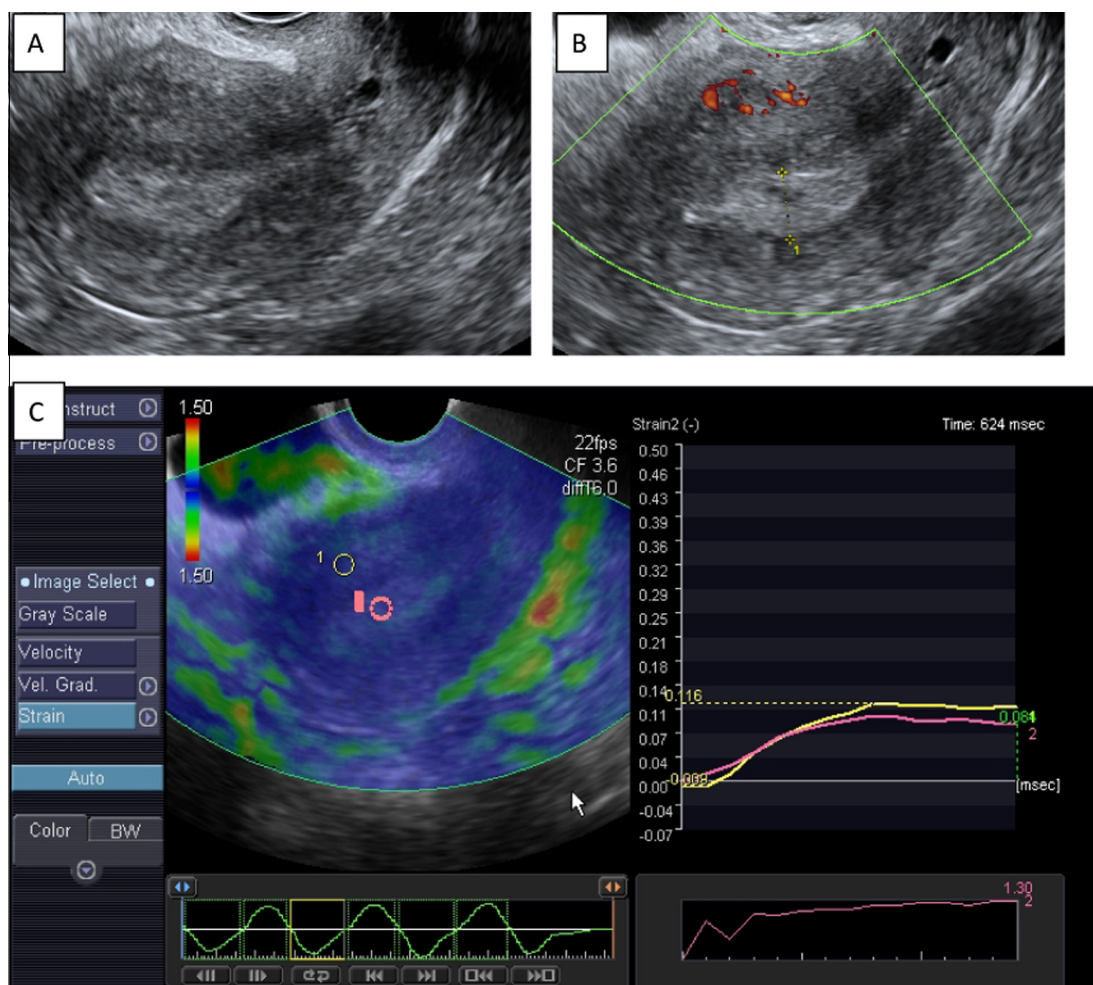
Ultrasound images of a female patient, aged 60 years with thickened endometrium (confirmed to be typical endometrial hyperplasia by pathological examination). B-mode ultrasound image (A), Power Doppler image (B) and TV elastogram (C) show endometrial thickness = 12 mm with no significant increase vascularity, green to light blue color and SR = 1.3.
